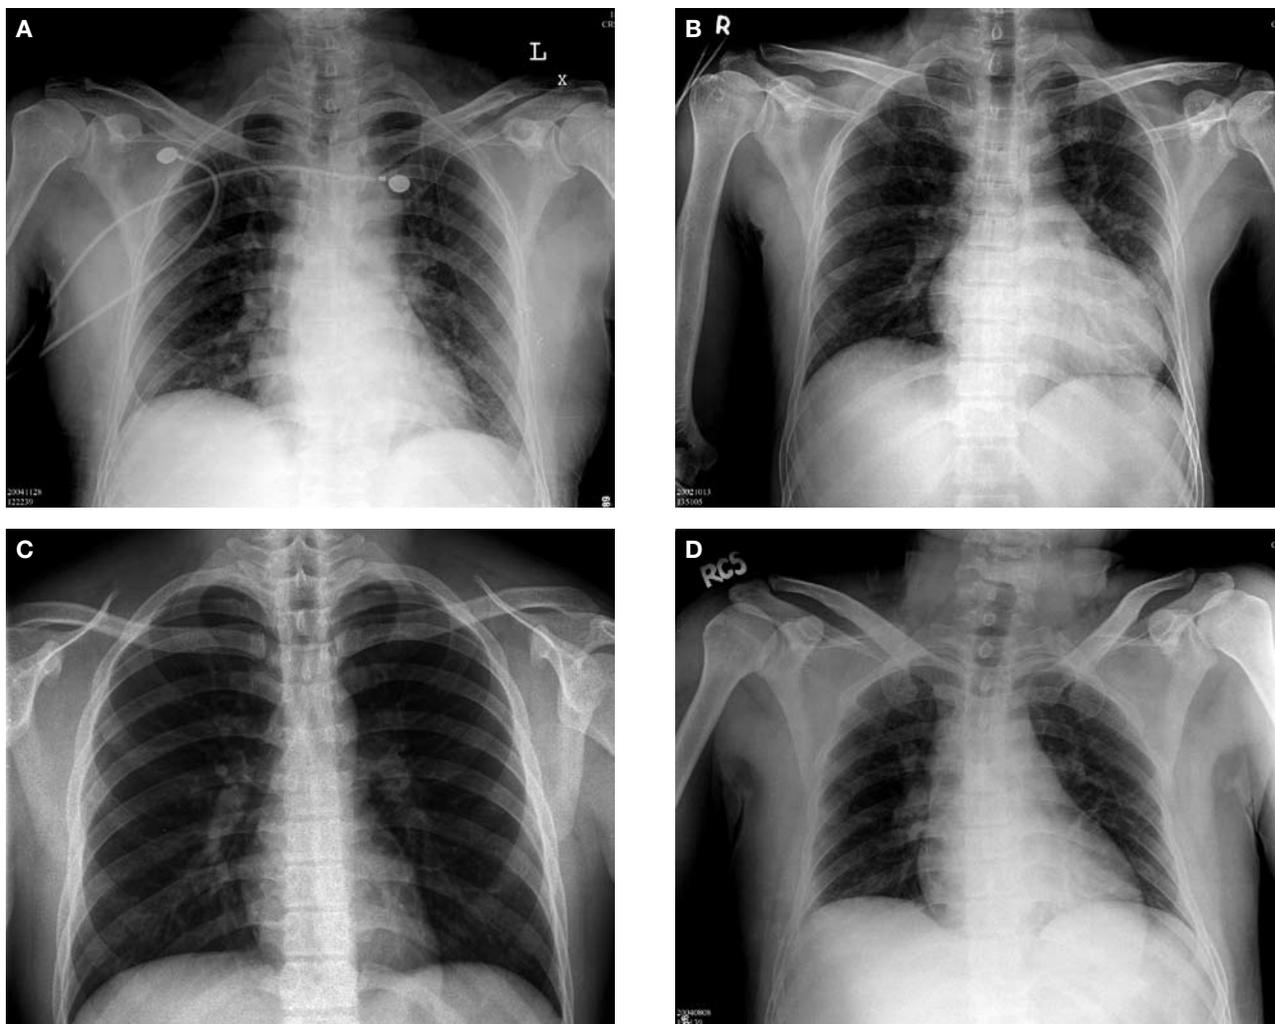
Four kinds of abnormal chest radiography. Small nodular density pattern (A); interstitial linear pattern (B); alveolar infiltration pattern (C); pleural effusion pattern (D).
